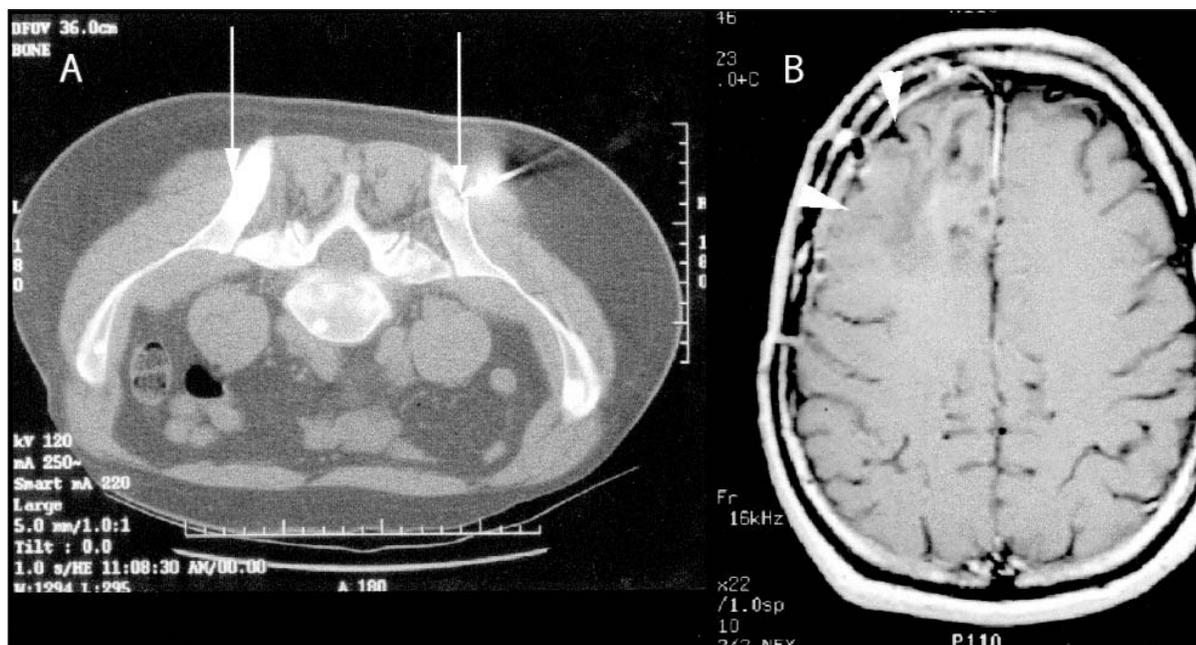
A. CT pelvis with intravenous contrast demonstrating multiple areas of hyperintensity representing increased uptake of contrast in areas of metastatic tumour to the wings of the ilia, posterior iliac spines (arrows), and vertebral body. The metallic object with artifact represents the needle insertion for CT-guided biopsy. B. MRI head with intravenous gadolinium contrast injection from 1999 demonstrating large right frontal mass with little to no enhancement, some encephalomalacia.
